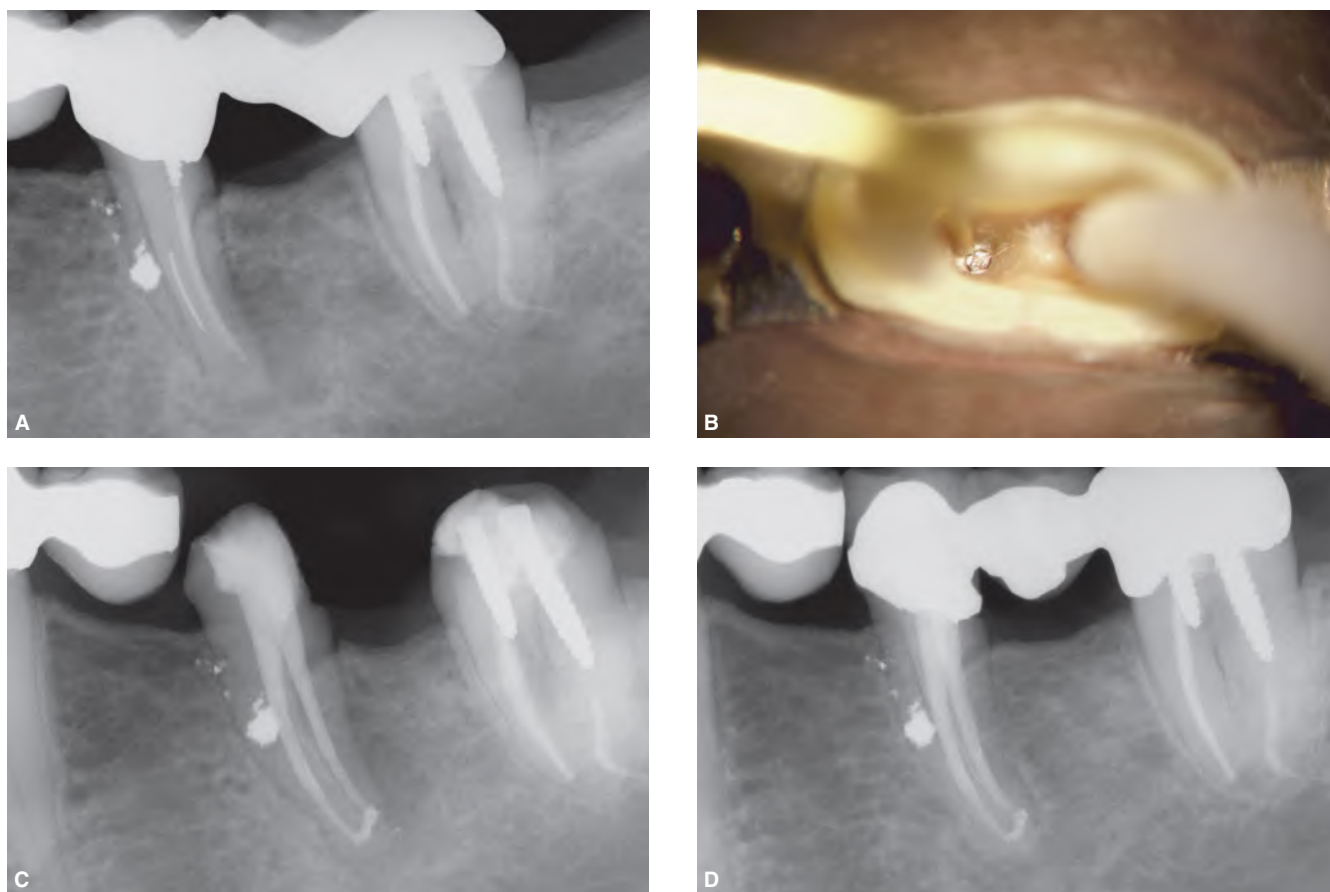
A. A failing endodontic treatment in a mandibular first molar. Note, a short screw post, a separated instrument and amalgam debris from the hemisection procedures. B. Photograph showing the splint removed, the post taken out, and an ultrasonic instrument trephining around the broken separated file. C. Posttreatment radiograph reveals successful retreatment. Note the third mesial system between the MB and ML canals. D. Eight-year recall radiograph showing three-dimensional retreatment, a new bridge and excellent periradicular healing.
